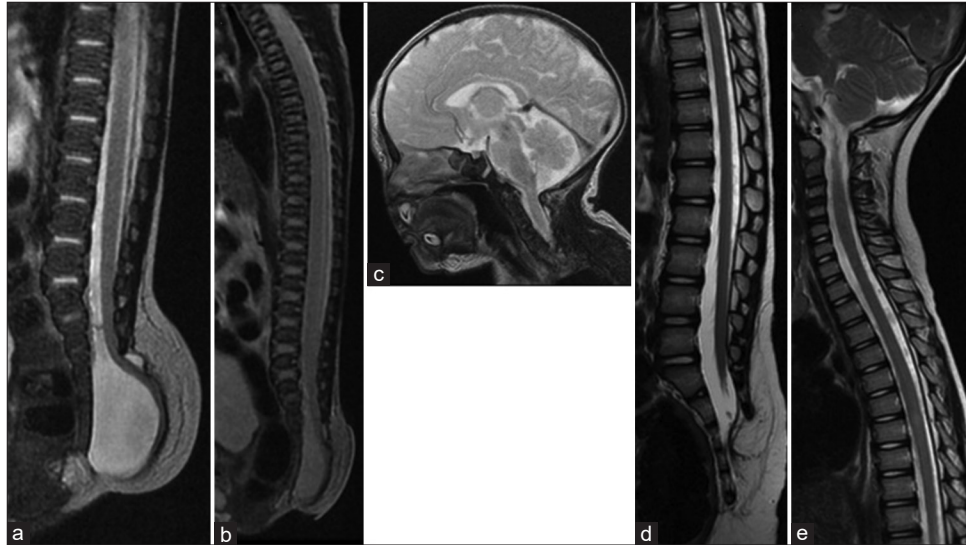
(a) Sagittal T2-weighted magnetic resonance (MR) image at birth showed the sacral lipomyelomeningocele. The spinal cord prolapsed from the sacral epidural space and tethered at the subcutaneous fat. (b and c) No obvious syringomyelia, Chiari malformation, and hydrocephalus were observed at birth. (d and e) Sagittal T2-weighted MR image at age 5 years showed no syrinx formation. Although the low-lying conus could be observed, the patient was asymptomatic; therefore, close observation was continued.
